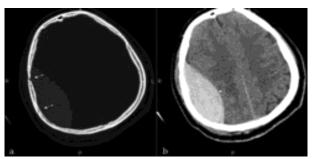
The brain was examined using a non-contrast CT scan, which revealed the presence of a biconvex hyperdense collection outside the brain tissue. This collection is connected with a fracture and is compatible with an extradural hematoma.
